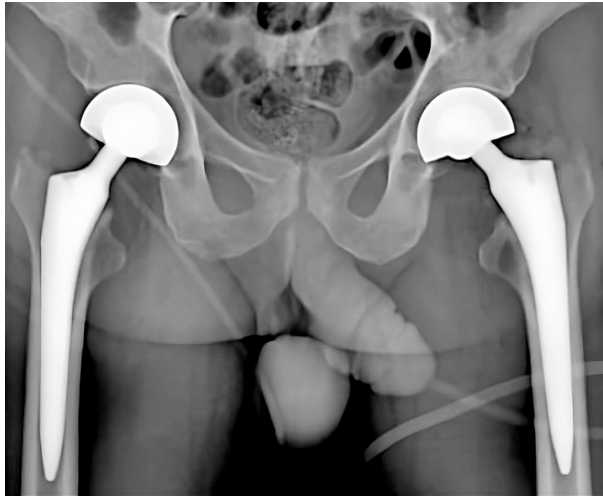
Radiograph was taken after the operation, cementless bipolar hemiarthroplasty.
